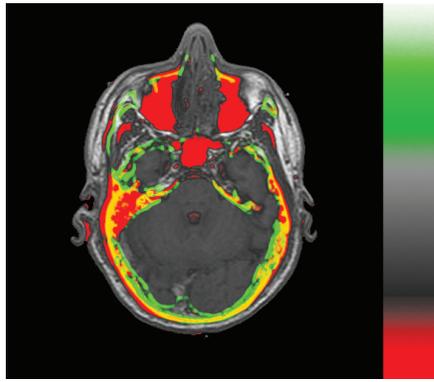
Bone tissue highlighted (red) in an MRI scan (same as in figure 2). CT representation of bone (same as in figure 1) superimposed (green). Common areas are represented in yellow.
